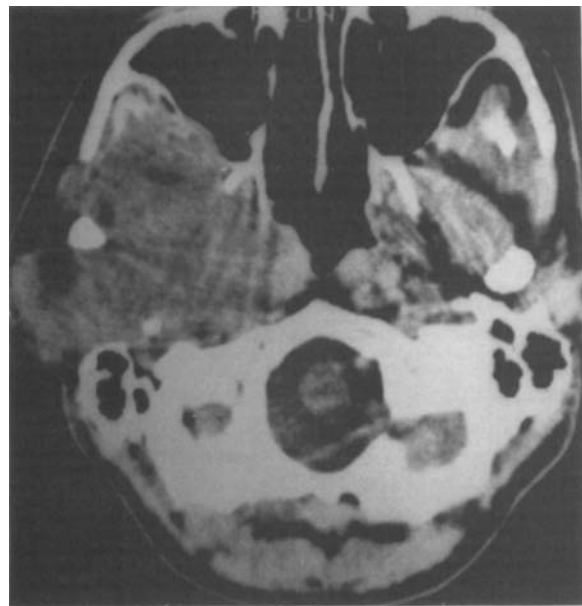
CT-scan showing the same neoplasm as in Fig. 1.
